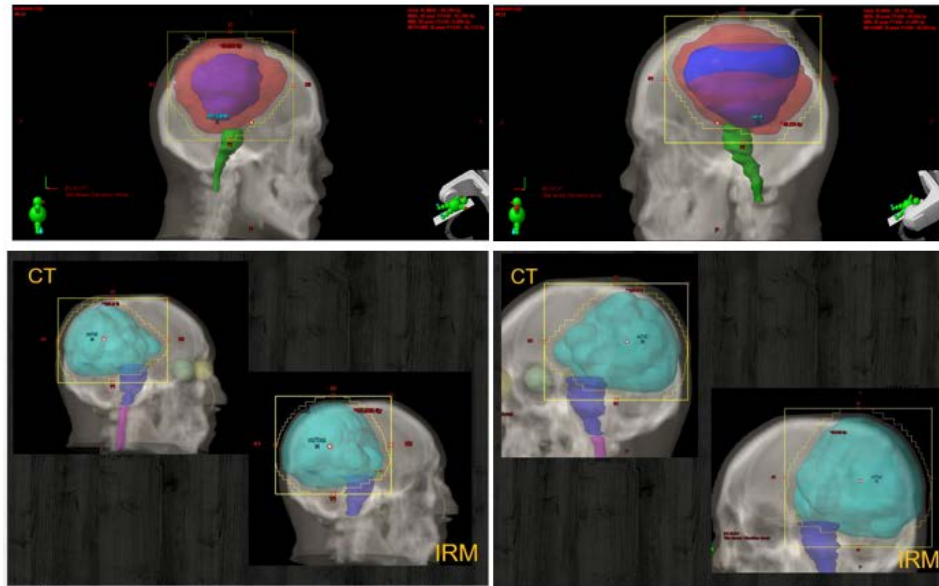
3D images showing difference between Glioma's PTV delineated on CT and on MRI images.
